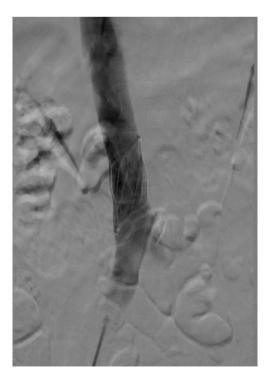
X-ray with contrast. Endovascular filter inserted to the inferior vena cava
